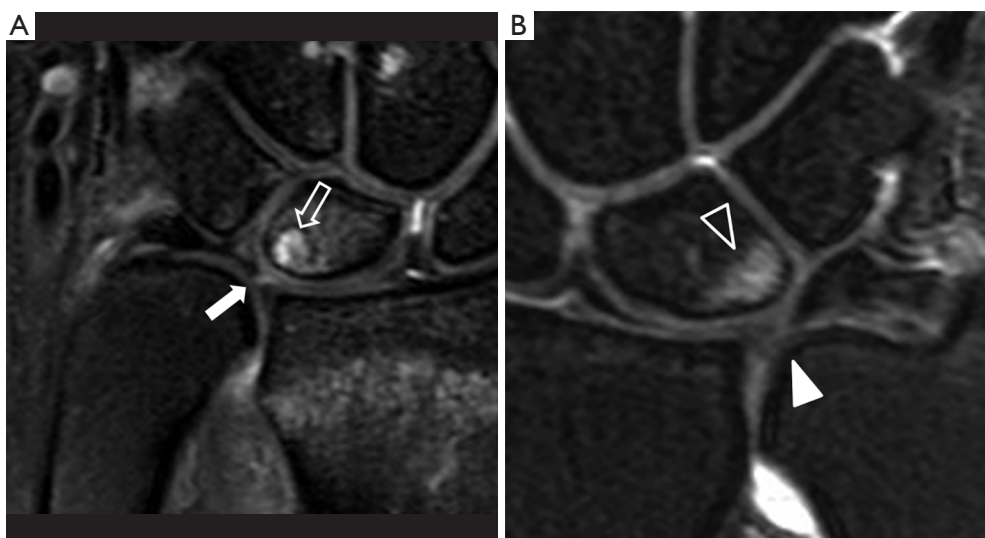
Ulnocarpal impaction. (A) Coronal proton density fat-suppressed MR image shows type 1a paracentral region tear (solid arrow) associated with subchondral cystic changes on the ulnar proximal aspect of the lunate (block arrow) consistent with ulnocarpal impaction. Mild ulnar positive variance is present; (B) coronal proton density fat-suppressed MR image of another patient also shows type 1a tear at the paracentral region of the TFCC (solid arrowhead) associated with subchondral cystic changes on the ulnar proximal aspect of the lunate (block arrowhead) with mild overlying cartilage irregularity. Features consistent with ulnocarpal impaction. TFCC, triangular fibrocartilage complex.
